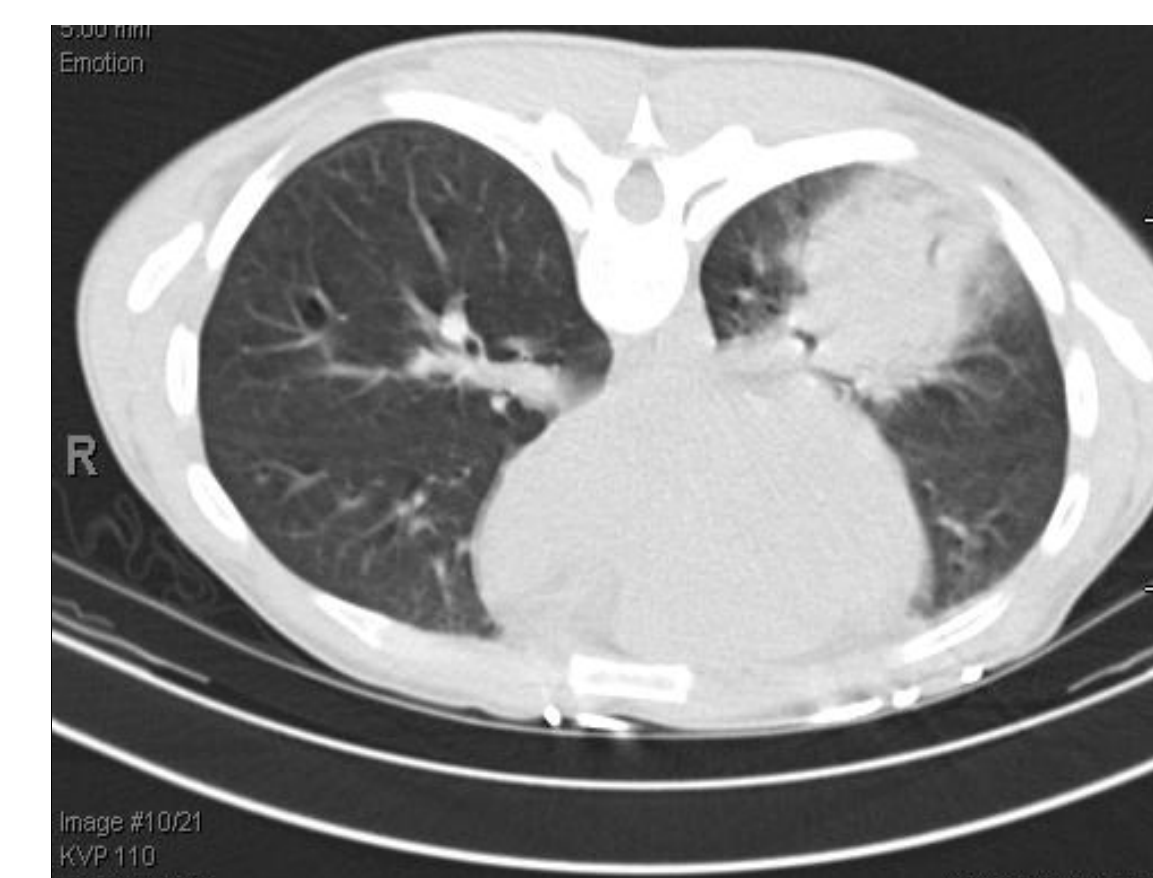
CT imaging of the chest demonstrated a left lower lobe mass
